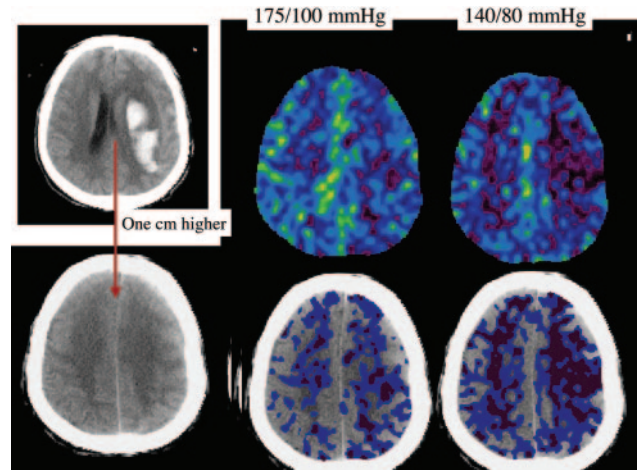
Perihematoma hypoperfusion demonstrated by xenon-enhanced CT scan. Imaging was performed 4 hours after the onset of right hemiparesis and aphasia in a 54-year old woman with history of hypertension. The xenon/CT cerebral blood flow images were obtained 1 cm above the level of the hematoma, initially at a blood pressure of 175/ 100 mm Hg and again 20 minutes later at a pressure of 140/80 mm Hg after intravenous treatment with labetalol. The lower blood pressure appears to result in more extensive tissue hypoperfusion. The lower images are windowed to show pixels with flow values below 20 cc/100gms/min in blue and pixels with values below 8 cc/100gms/min in lavender.
